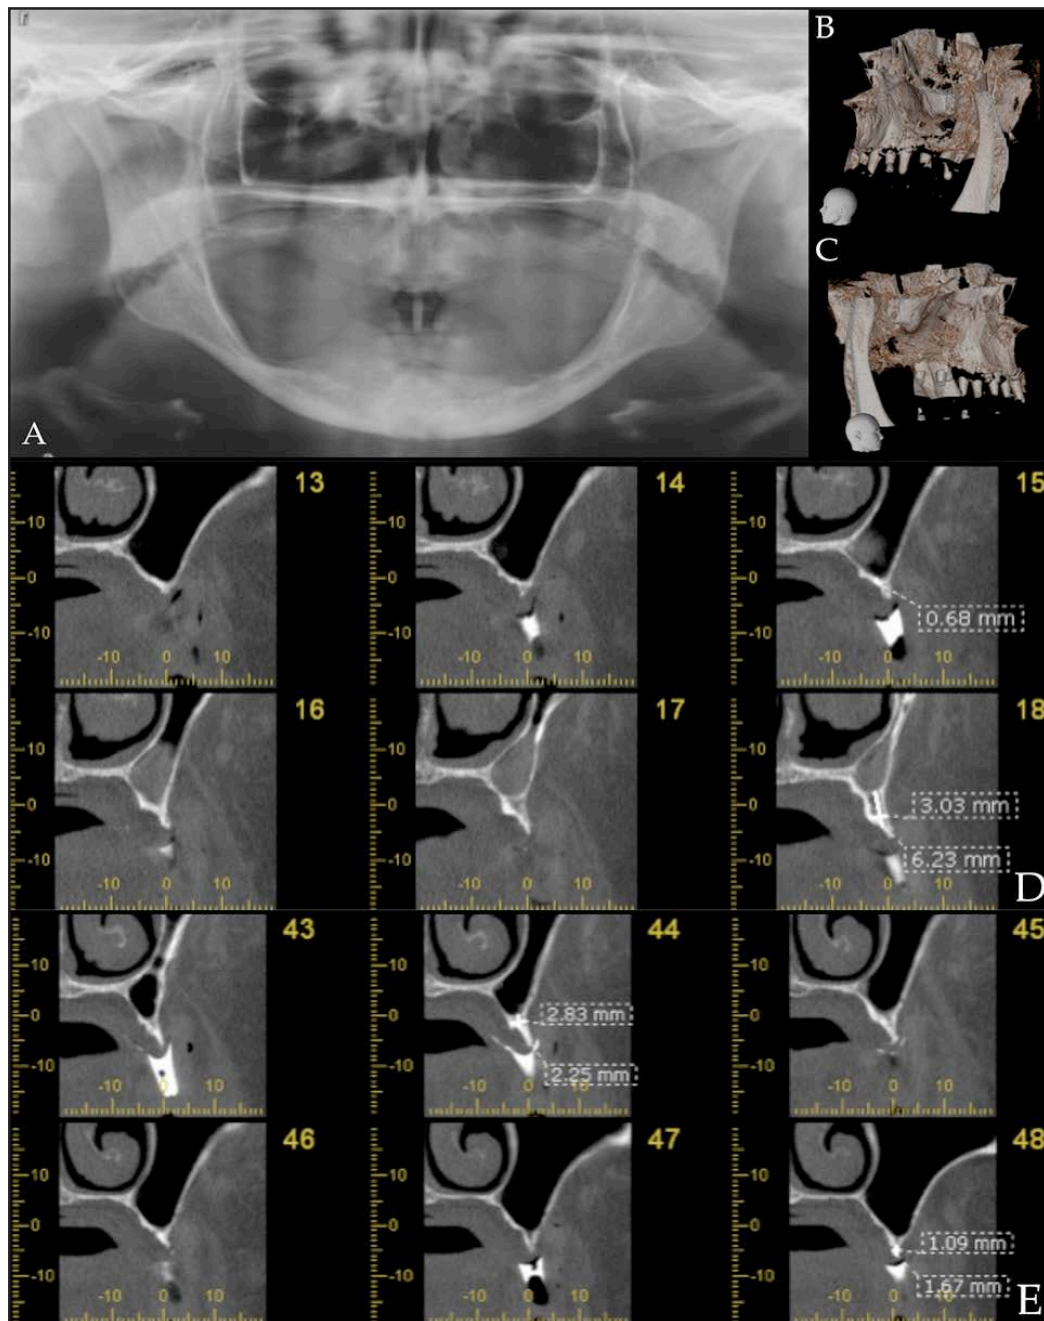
Pre-operative diagnostic images. All images show a dramatic loss of bone in the upper left and right maxilla. A: Panoramic X-ray showing edentulous maxilla and mandible. B, C: 3-D reconstruction of the left (B) and right (C) maxilla with the surgical stent. D, E: Coronal cut from a cone beam computed tomography scan from the left (D) and right (E) maxilla.
